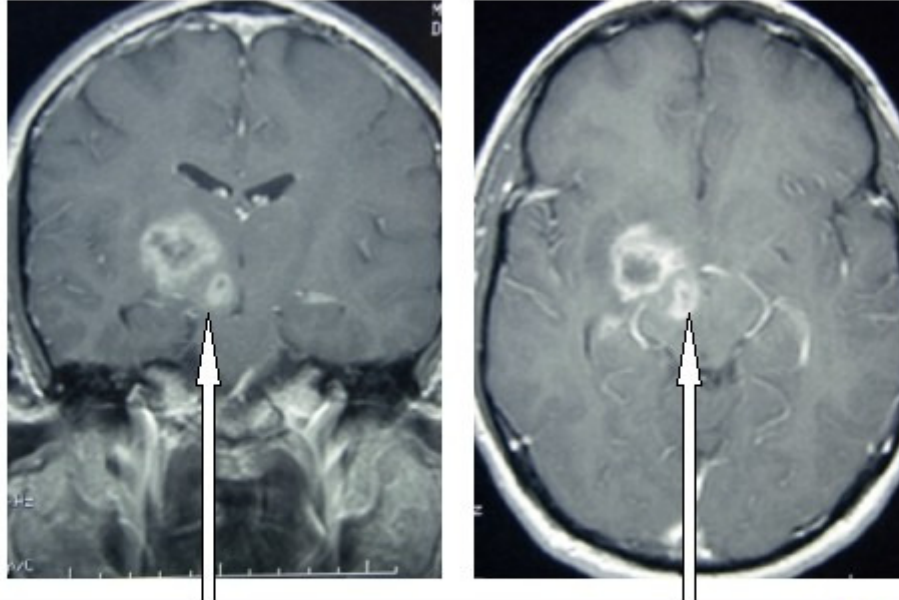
(Left): MRI Scan (Coronal View-Gadolinium enhanced). 45 year old male with a deep seated Right Thalamic region Glioblastoma with direct infiltration of the Brainstem (Arrow).
